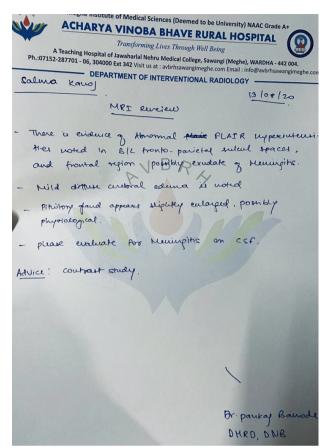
Magnetic Resonance Imaging Brain for our patient.
